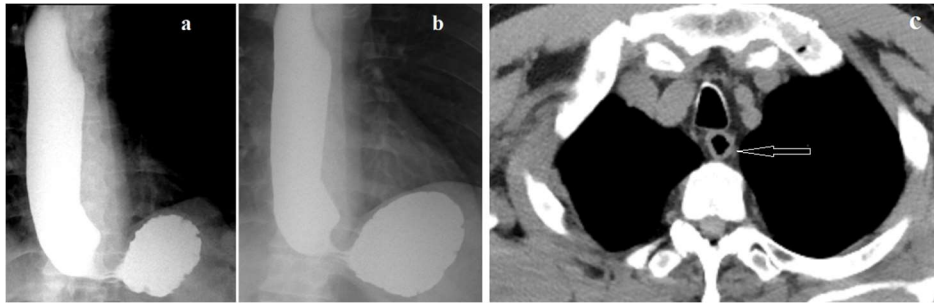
X-ray examination of EGJ during high pressure in the stomach. (a). Study at age 75. The esophagus is dilated (3.8 cm). The narrow segment between the esophagus and the stomach \approx 1.4 cm long is a contracted LES, which is more than 2 times shorter than normal. (b). At the age of 77 years, radiographic appearance no change. XIR is 2.7. (c). CT scan at the level of the upper esophagus at age 74. There was gas along the entire length of the esophagus (arrow).
